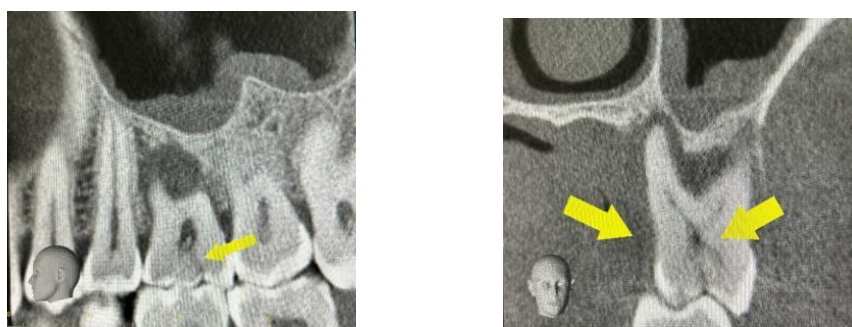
CBCT images of the SAGITTAL SECTIONS depicting the same
